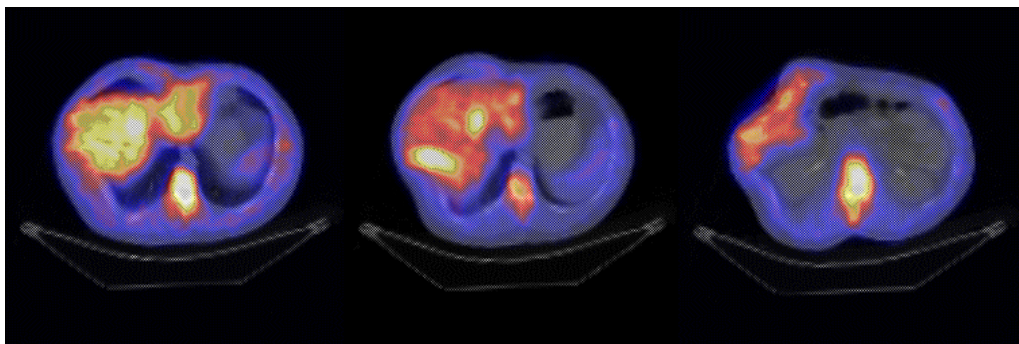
The floating image (SPET) in “STD Gamma-II” colour scale overlays the reference image (CT) in gray after non-rigid registration. The mismatch of the liver image between SPET and CT in three axial slices from upper (left), middle and lower (right) abdominal region is not improved after registration.
